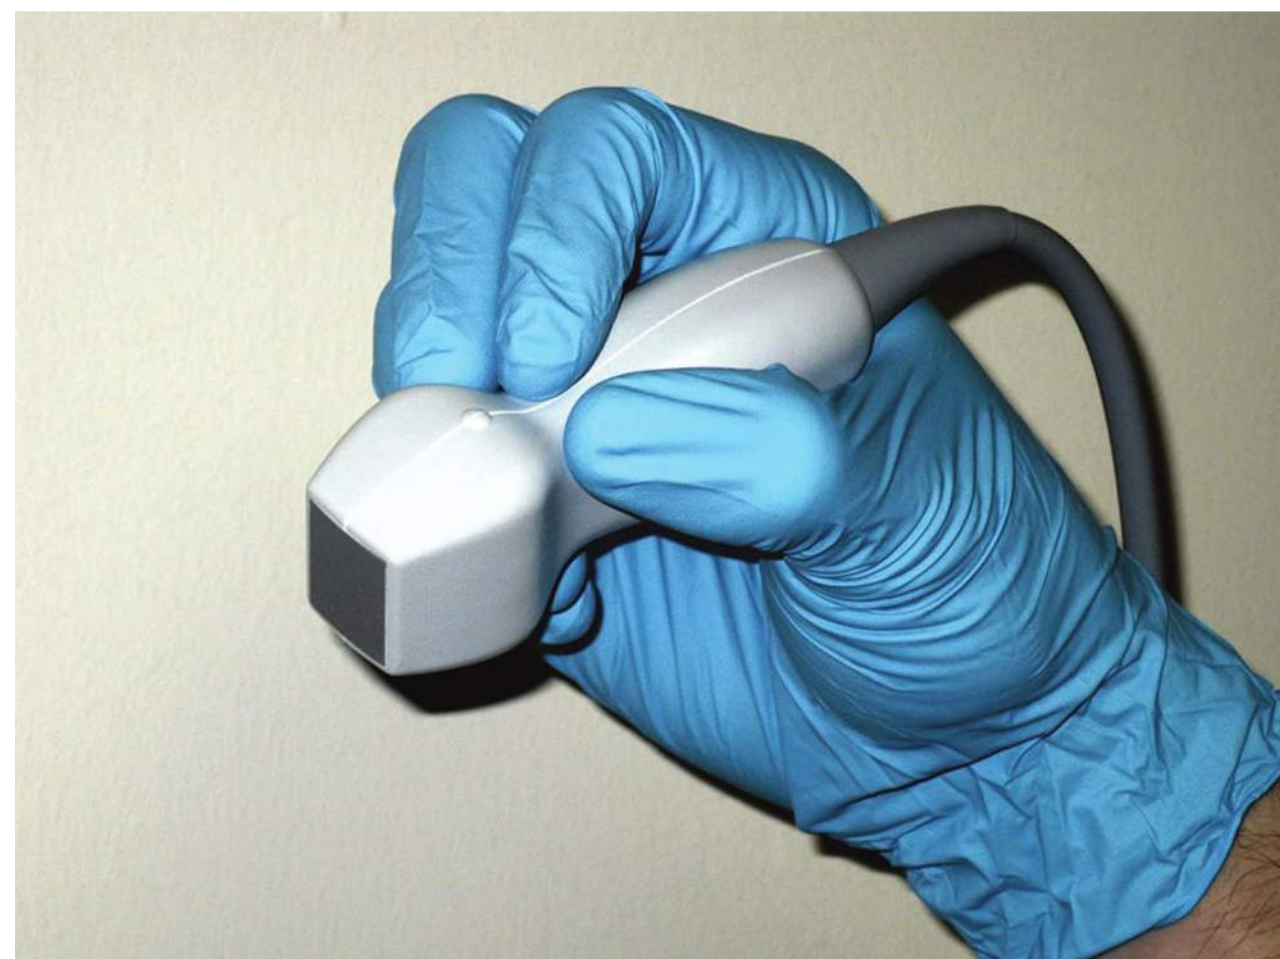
Phased array transducer. Its small footprint and superior frame rate make it the transducer of choice for echocardiography.
